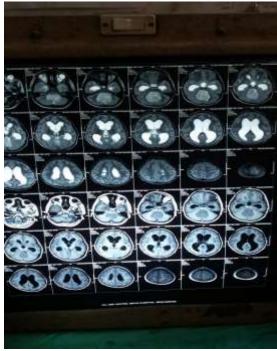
MRI showing medulloblastoma and moderate hydrocephalus.
